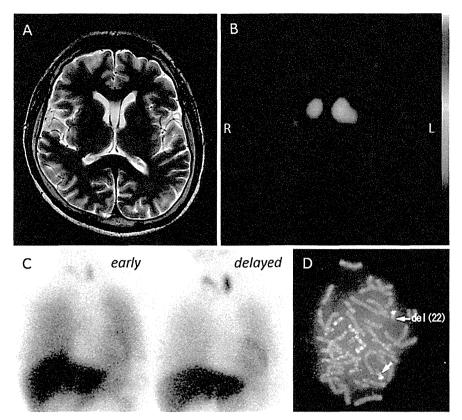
(A) T2-weighted brain MRI showing cavum vergae. (B) ¹²³I-FP-CIT-SPECT revealed a reduced uptake in both of the putamen, which was more prominent on the right. (C) ¹²³I-metaiodobenzylguanidine scintigraphy showing normal cardiac uptake in the early and delayed phases. (D) A FISH chromosome analysis indicating del(22) (q11.2q11.2)(TUPLE1-).
